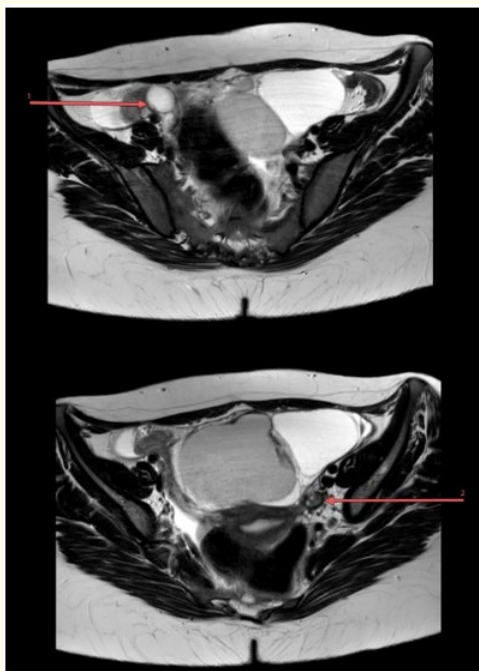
Pelvic MRI, axial T2 sequence, showing the right (1) and left (2) ovaries.
